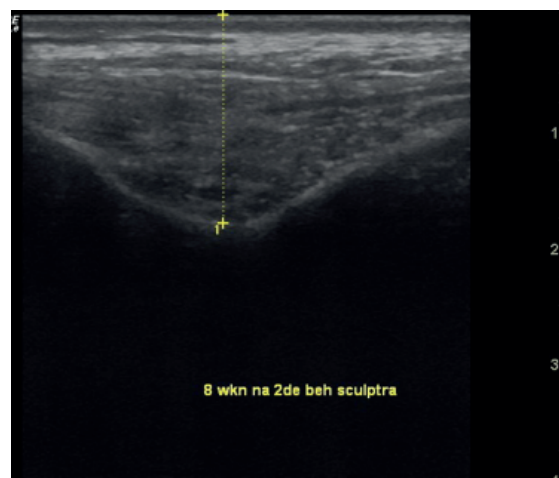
Polylactic acid injected 7 weeks before above the periosteal level of the temple. The distance between the skin and the bone of the temple area was measured using ultrasound.
